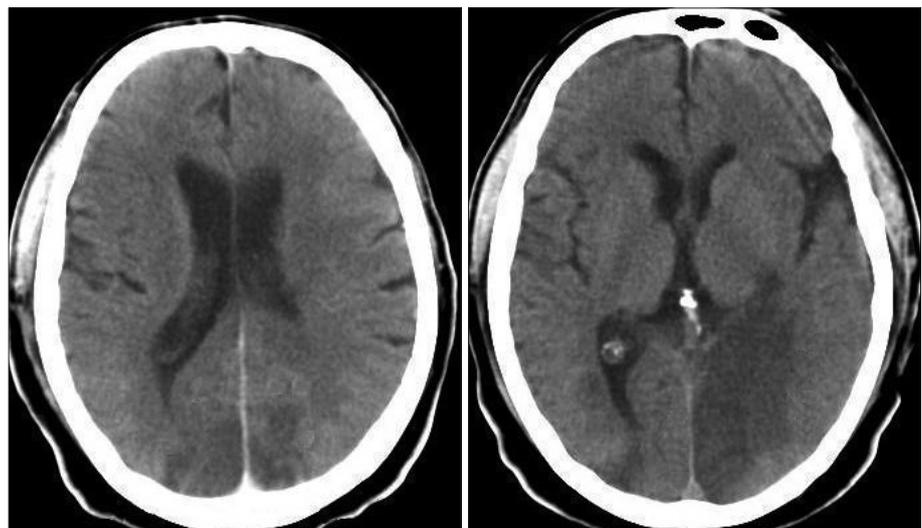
Computed tomography of the brain revealed infarction of both occipital lobes and of the subcortical white matter of the left parietal lobe.
